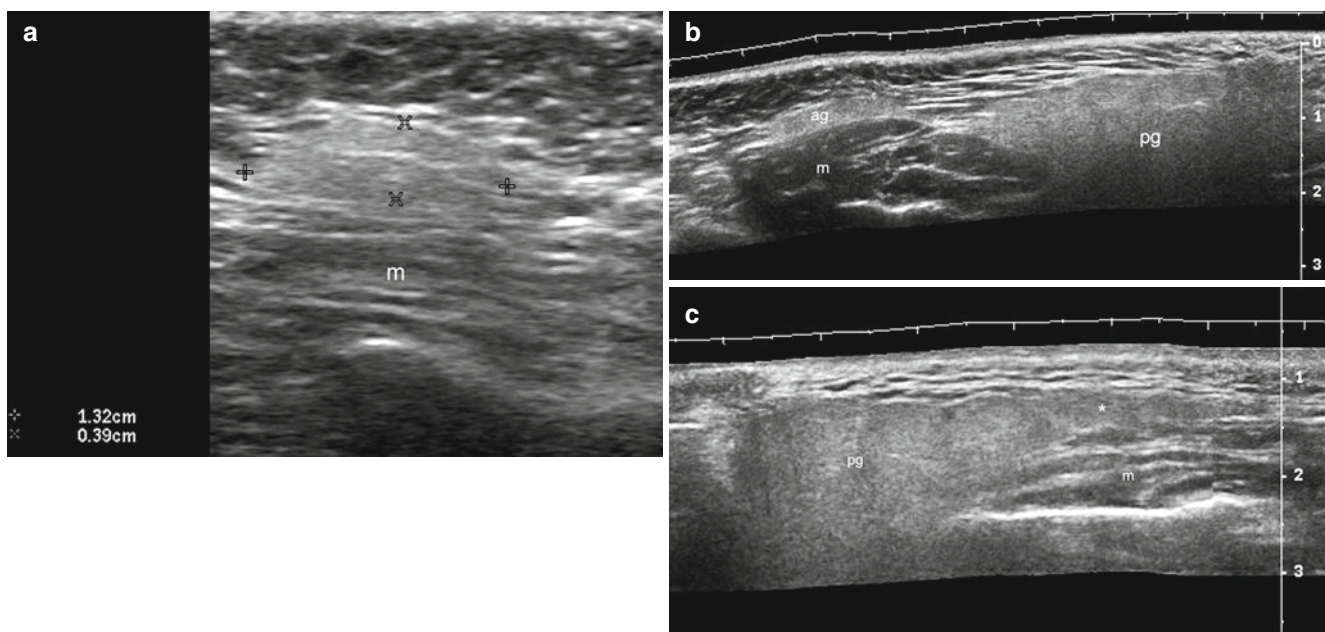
(a–c) Accessory parotid gland and prominent anterior lobe of the parotid gland. (a) Grey scale ultrasound image (transverse view) demonstrates a 1.39 cm (wide) × 0.39 cm (deep) well-defined, oval-shaped, hyperechoic structure (between markers) that corresponds to an accessory parotid gland. This variant is located on top of the masseter muscle. (b) Grey scale ultrasound image (extended transverse view) shows a well-defined oval-shaped hyperechoic
